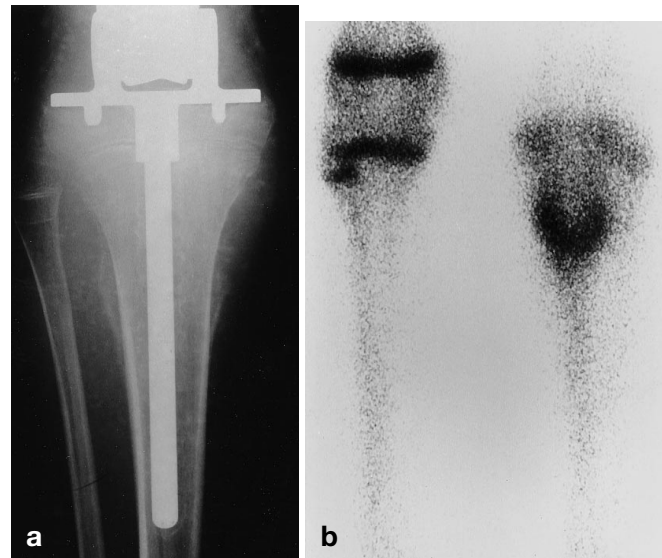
a, b. A 22-year-old male 18 months following distal femoral endoprosthesis replacement for an osteosarcoma. a Anteroposterior radiograph showing lysis and periosteal newbone formation indicating local recurrence in the proximal tibia. b Three-hour posterior bone scintigraphy showing increased activity at the site of the recurrence
